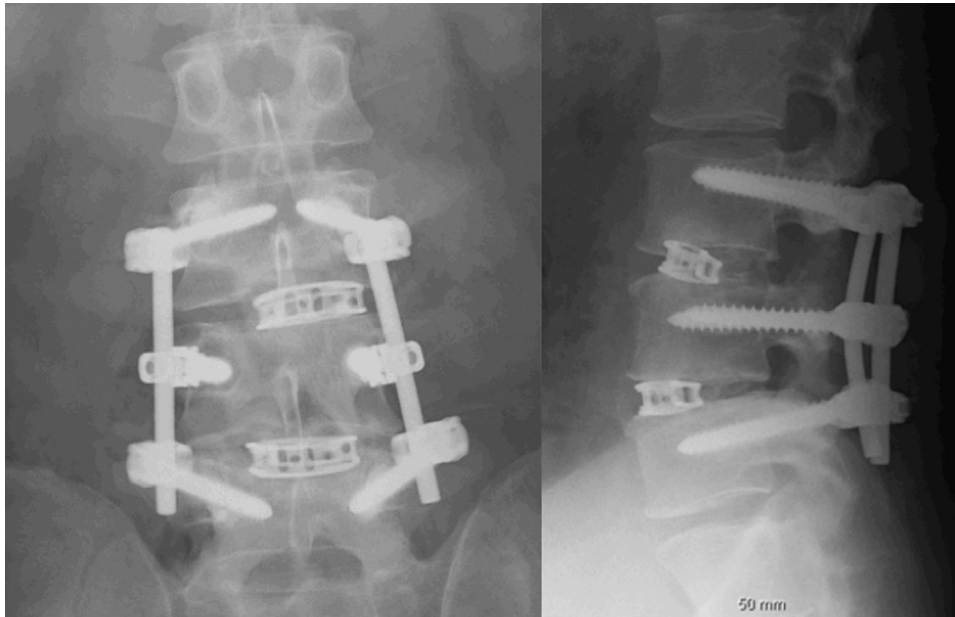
Postoperative plain X-ray anteroposterior and lateral views of patient 1 showing transforaminal lumbar interbody fusion at the same segments.
